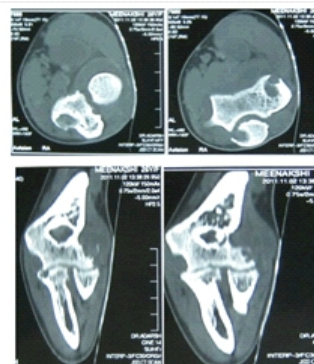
Axial and coronal plain CT of right elbow joint shows multiple well defined non sclerotic lytic lesions in both humeralcondyles,olecranon and radial head region with synovial thickening and joint effusion
